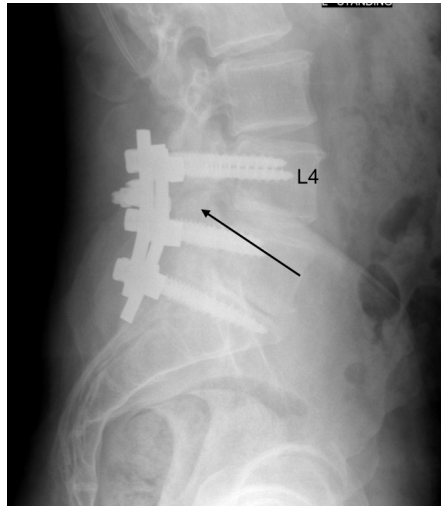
2-week post-operative, standing, left lateral lumbar spine x-ray showing intact pedicle screws and rods at L4-S1.
